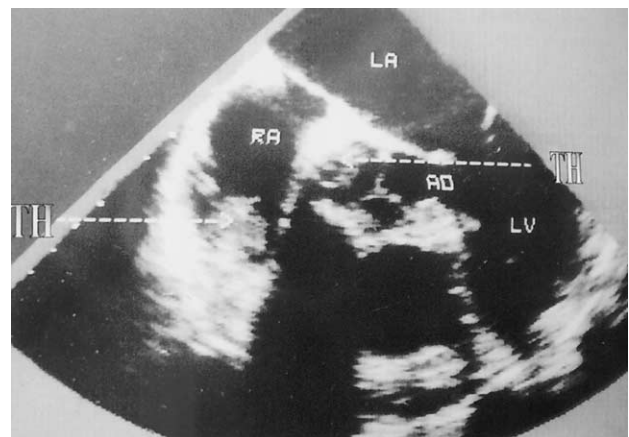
Transesophageal echocardiography images revealed thrombosis (TH) into the right atrium (RA) and near the proximal suture of the Dacron aortic graft (AO). (LA = left atria; LV = left ventricle.)
